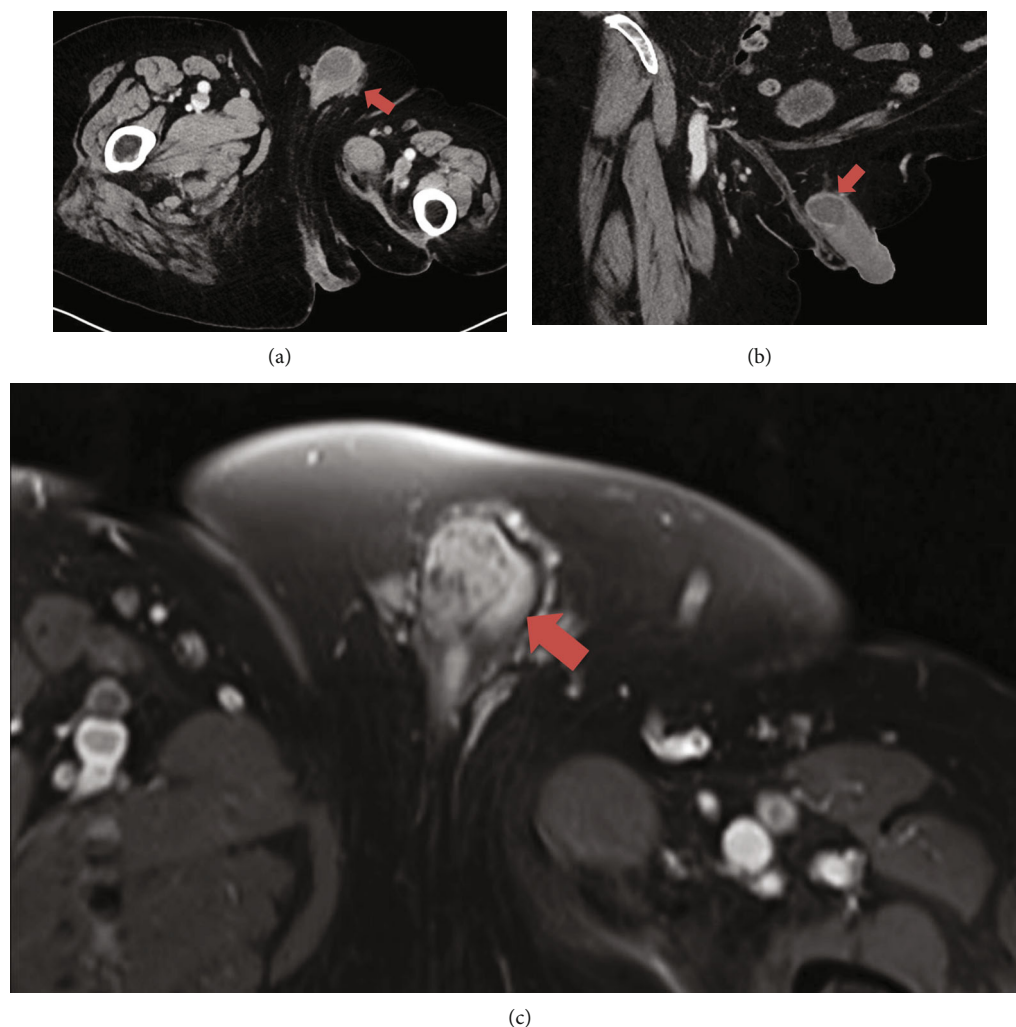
Preoperative MR imaging: (a) axial, (b) coronal, and (c) axial in T1 perfusion. Red arrows mark chordoma metastasis at the right corpus cavernosum of the penis as solid mass of about  $2.3 \times 3.0$  cm.
